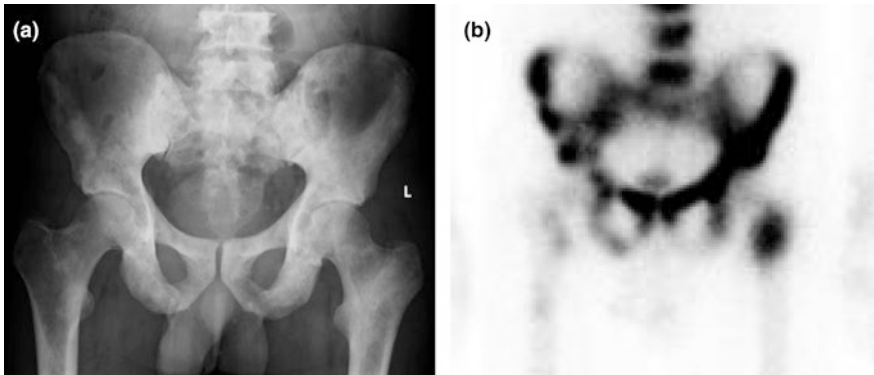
A gentleman with lower back pain and elevated PSA underwent investigation. An AP pelvic radiograph of the pelvis (a) demonstrated increased sclerosis throughout the pelvic bones, left femur and lower lumbar spine. A nuclear medicine bone scan (b) confirms increased tracer uptake in the same regions. These appearances are typical of metastatic prostate cancer
